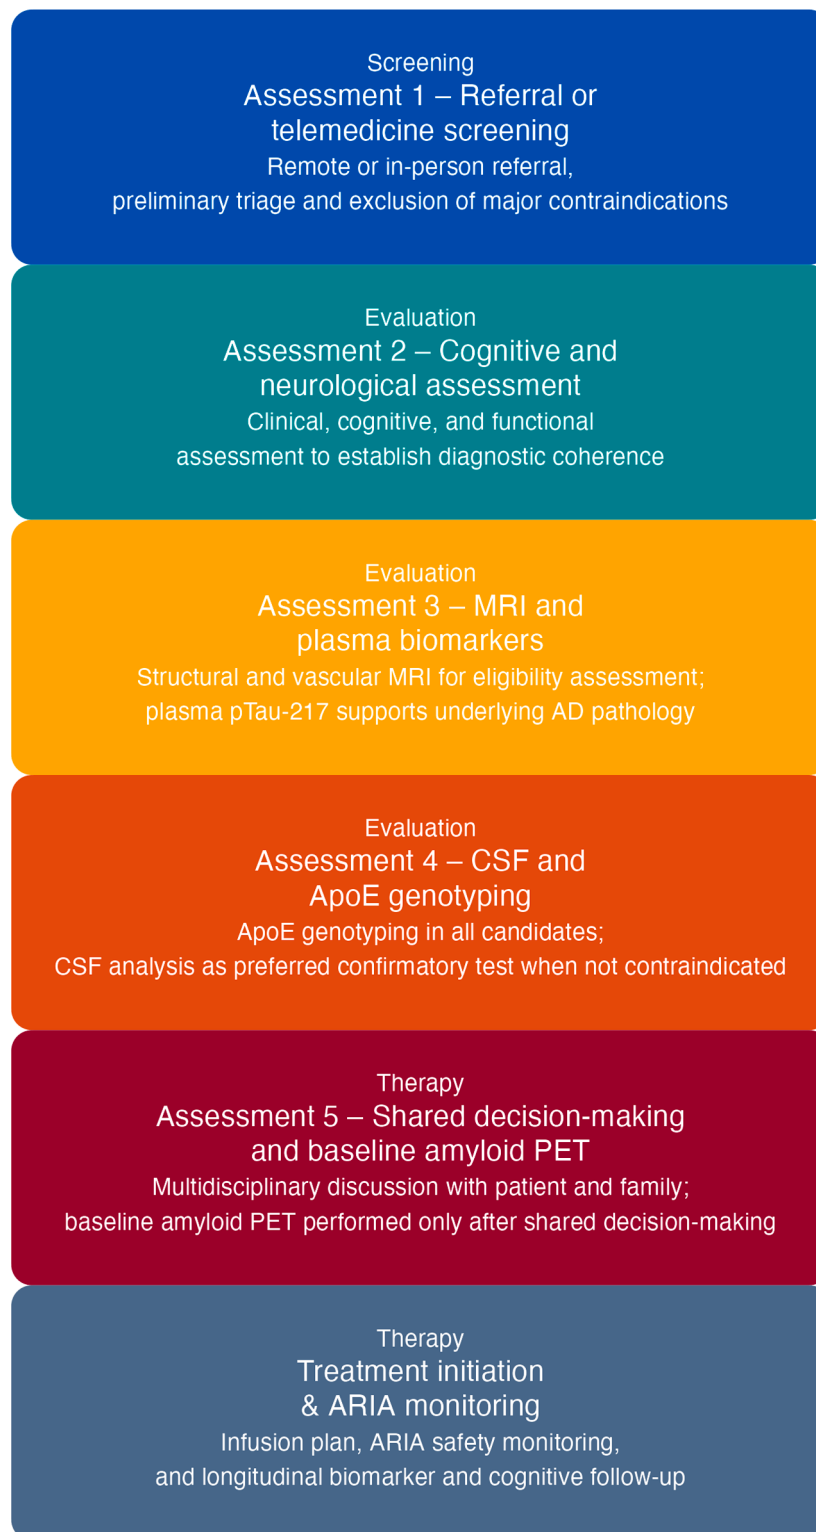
Patient journey for eligibility and initiation of anti-amyloid therapy. A fast-track pathway designed to ensure timely assessment and treatment readiness in candidates for anti-amyloid monoclonal antibodies. Screening includes referral or telemedicine triage and exclusion of major contraindications. Clinical and functional assessment establishes diagnostic coherence, followed by MRI-based eligibility
